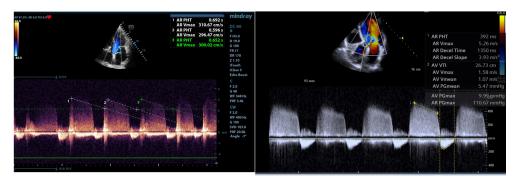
b.19. Estimation of AR severity by PHT method (5-chambers view, color and CW Doppler); left: mild AR (PHT = 692 ms; envelope of AR is not so intense); right: moderate AR (PHT = 392 ms; intense signal of the envelope of regurgitation flow)
